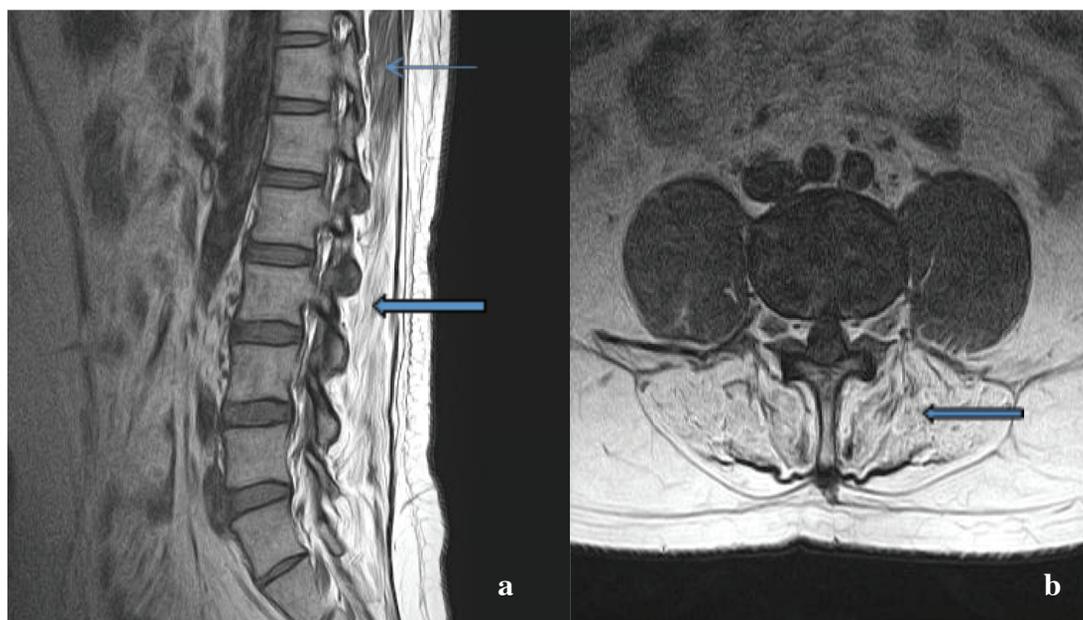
Sagittal (a) and axial (b) T₁ weighted MRI of the lumbar spine demonstrating severe atrophy of the lumbar paraspinal muscles (thick arrows) and preserved thoracic paraspinal muscles (thin arrow).
